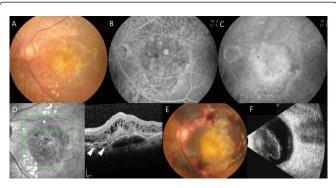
Ophthalmic examination in case 2. A: Early-phase fluorescein angiography shows a hyperfluorescent area on the macula with blocked fluorescence and multiple brighter spots (arrows). B: Late-phase fluorescein angiography. C: Optical coherence tomography shows pigmented epithelium detachment with hyper-reflectivity localized underneath the dome, raising suspicion for a polypoidal choroidal vasculopathy-associated polyp at the site corresponding to the early brighter spot on fluorescein angiography (arrow head). D: Optical coherence tomography after three monthly injections of ranibizumab with a suspicious polypoidal choroidal vasculopathy-associated polyp (arrow head). E. Fundus photography one month after the first aflibercept injection. F. B-scan ultrasonography six weeks after the first aflibercept injection.
